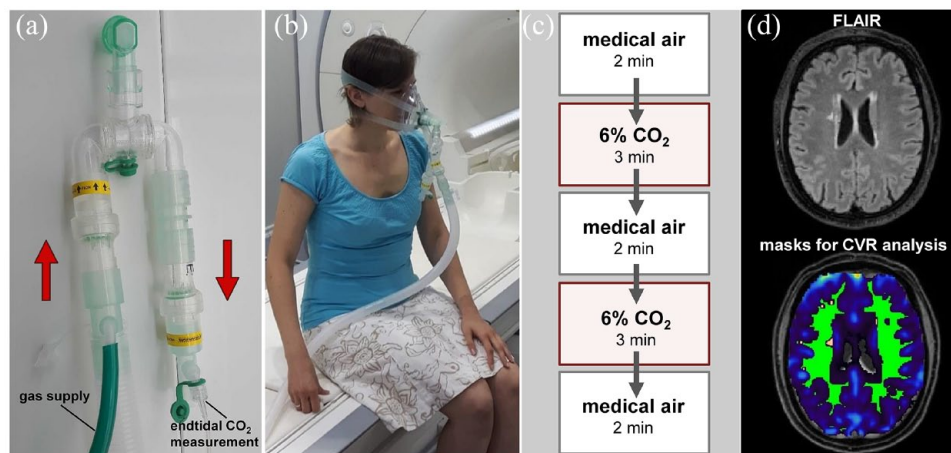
Assessment of the primary outcome measure in TREAT-SVDs trial. Shown are the technical set-up of the breathing circuit for application of the hypercapnic challenge and measurement of end tidal CO₂ (a), the fixed breathing circuit before positioning in the MRI scanner enabling continuous and controlled breathing of medical air or 6% CO₂ for quantification of cerebrovascular reactivity (CVR) (b), the breathing paradigm with alternating medical air and 6% CO₂ (c), and an exemplary FLAIR scan slice from a study participant with the corresponding masks for CVR analysis (d). The primary endpoint is change in CVR from baseline to treatment in normal-appearing white matter (green area). Further analyses include CVR in white matter hyperintensities (yellow area) and in subcortical grey matter.
